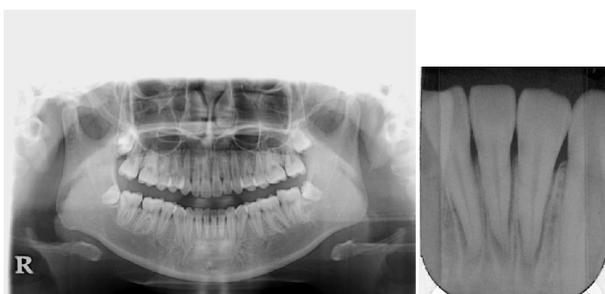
Panoramic and mandibular anterior tooth dental X-ray photographs.
